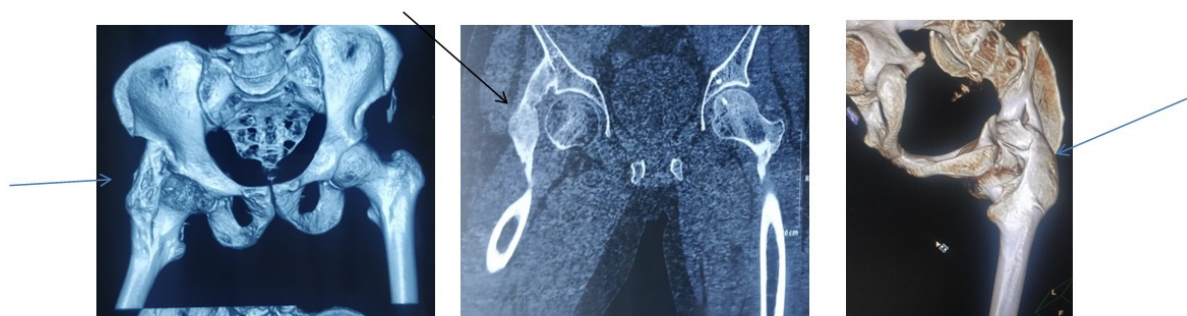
3D-CT sections showing extent of ankylosis anteriorly, Cut sections and posteriorly.
